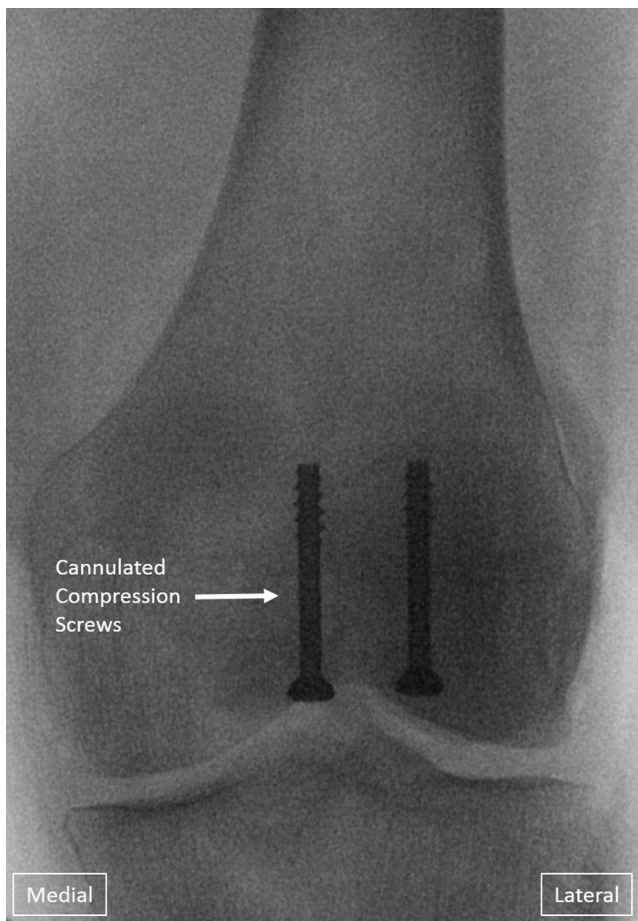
Patella fracture fixation in left knee, final intra-operative anteroposterior radiograph. Radiograph at the completion of the procedure demonstrating compression of simple transverse fracture through the middle third of the patella using 2 cannulated compression screws with tensioned cerclage suture.
